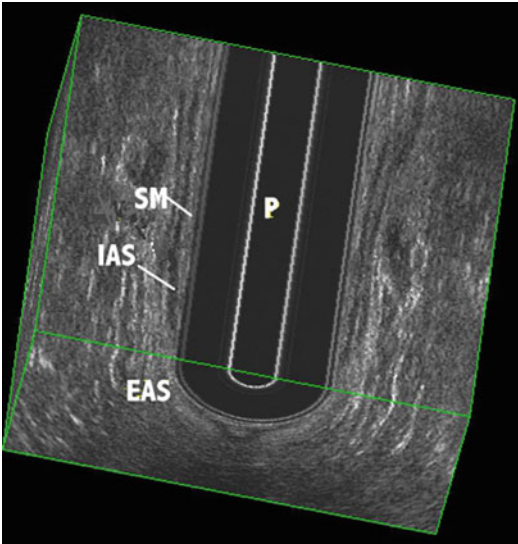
3D anal ultrasound of the anal sphincter, frontal view. The external anal sphincter (*EAS*) is longer and runs more distal than the internal anal sphincter (*IAS*)
